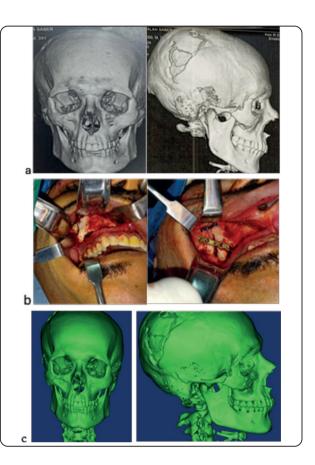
Showing a- The preoperative radiographs, b- The intra-oral maxillary vestibular approach and reduction and fixation of the maxillary buttress, and c- The postoperative radiographs.
